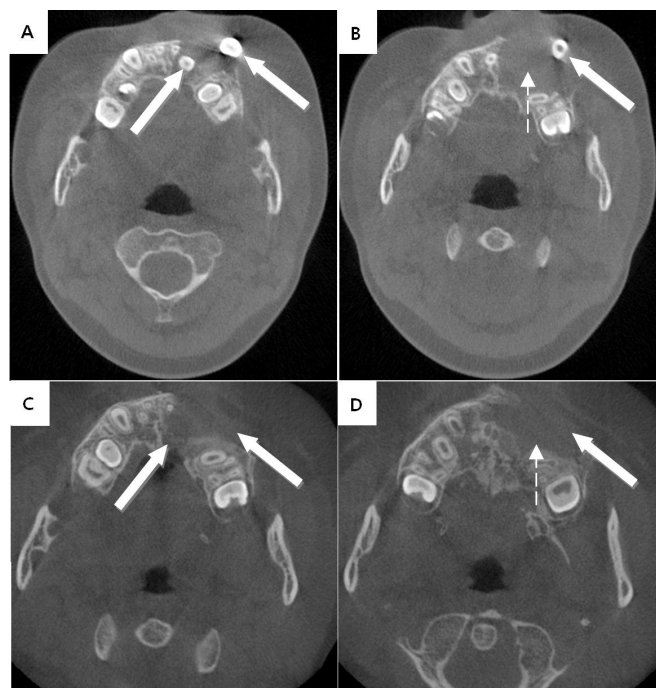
Total of three supernumerary teeth cyst (thick arrows) and dentigerous cyst (dotted arrow) in initial cone-beam computed tomography (A, B). Supernumerary teeth (thick arrows) and dentigerous cyst (dotted arrow) are completely disappeared in repeated cone beam CT after 3 months (C, D).
